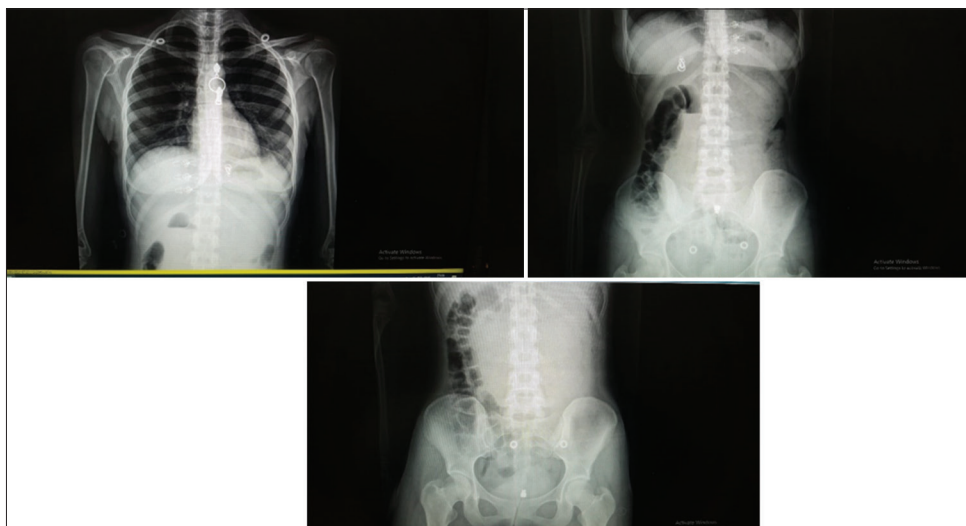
Plain X-ray Films of the Chest and The Abdomen
